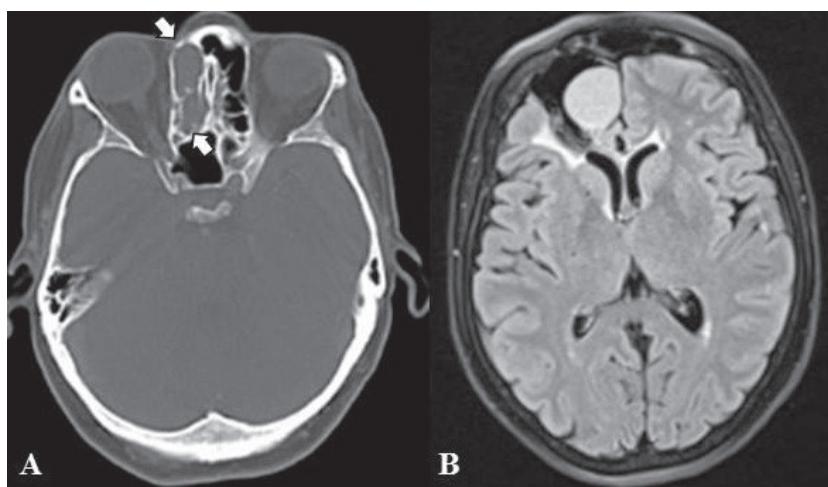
Mucocele affecting the anterior and posterior ethmoidal cells in a patient suffering from headache for 2 years. (A) CT (bone window) – obscurity of the right ethmoidal cells (white arrow); (B) T2 FLAIR MRI indicating high signal intensity lesion that invades the intracranial space and compresses the right frontal lobe.
